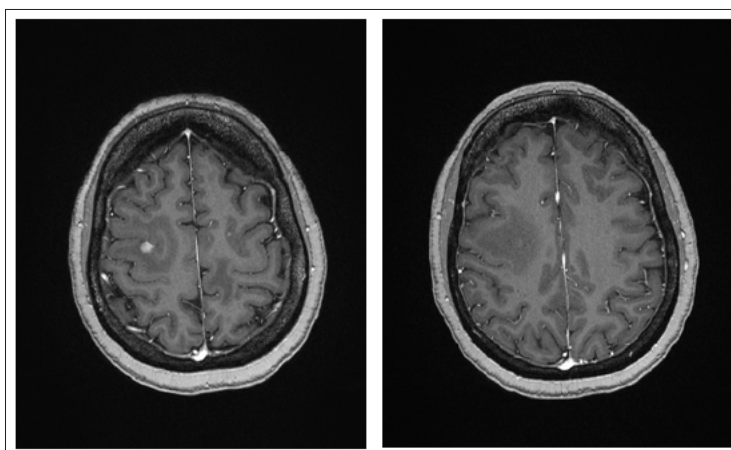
MRI brain May 2018 after treatment 2 months of treatment with Olaparib showing resolution of all lesions except the right posterior frontal lobe lesion.
